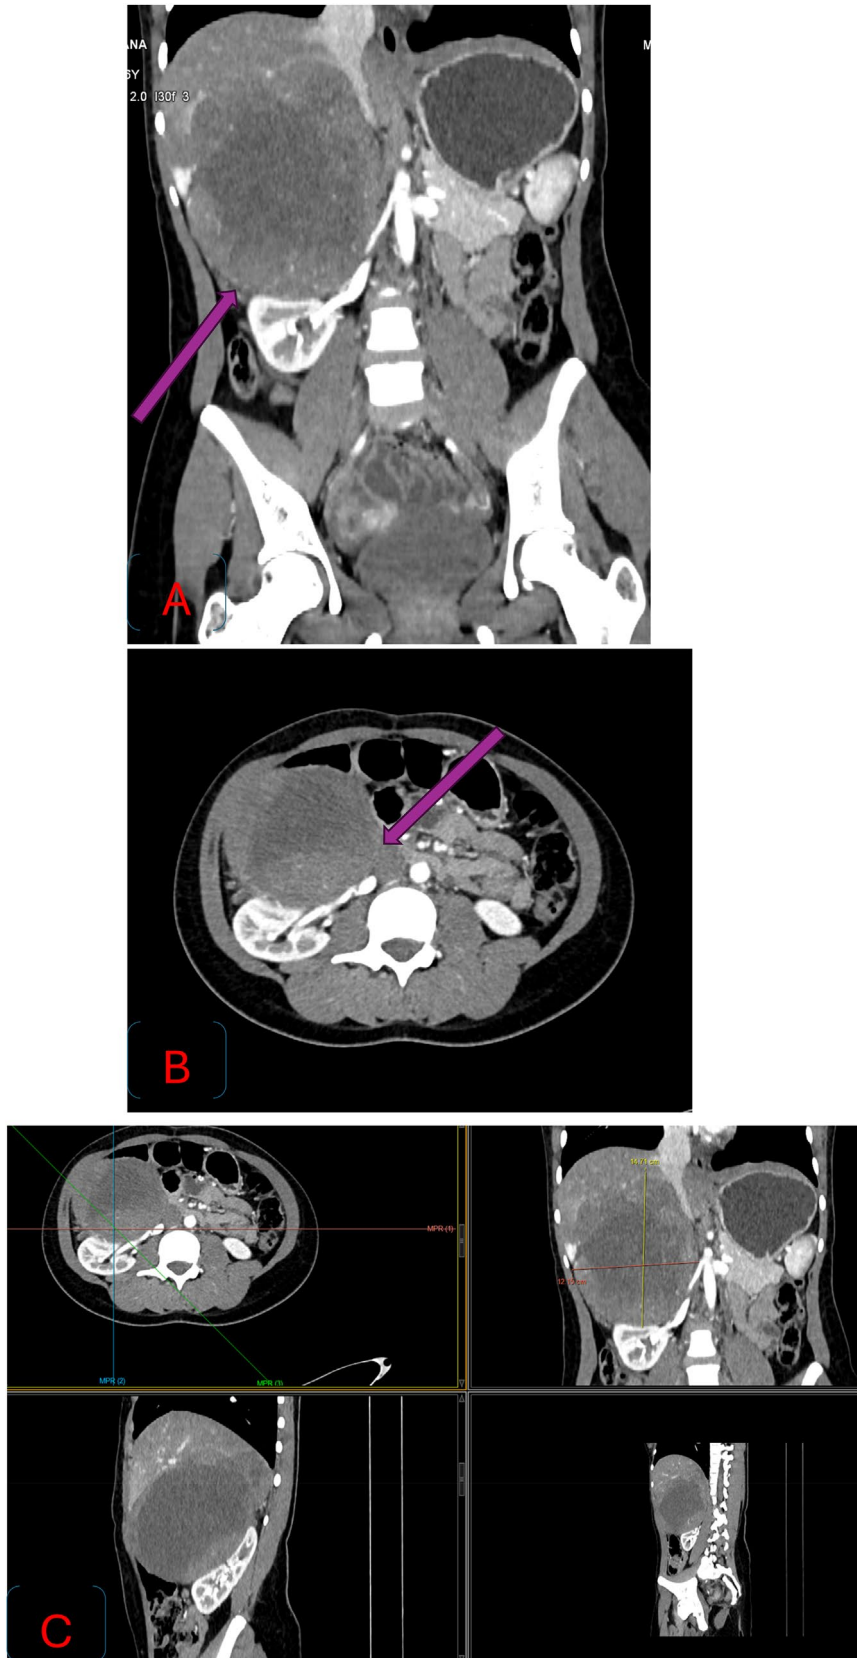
(A–C) Abdominal-pelvic contrast-enhanced CT scan in coronal, axial, and sagittal views showing a large right-sided retroperitoneal mass with heterogeneous enhancement. The mass is displacing the right kidney, inferior vena cava (IVC), aorta, and right renal artery anterosuperiorly, causing medial displacement of the liver and gallbladder. No evidence of vascular involvement is observed.
